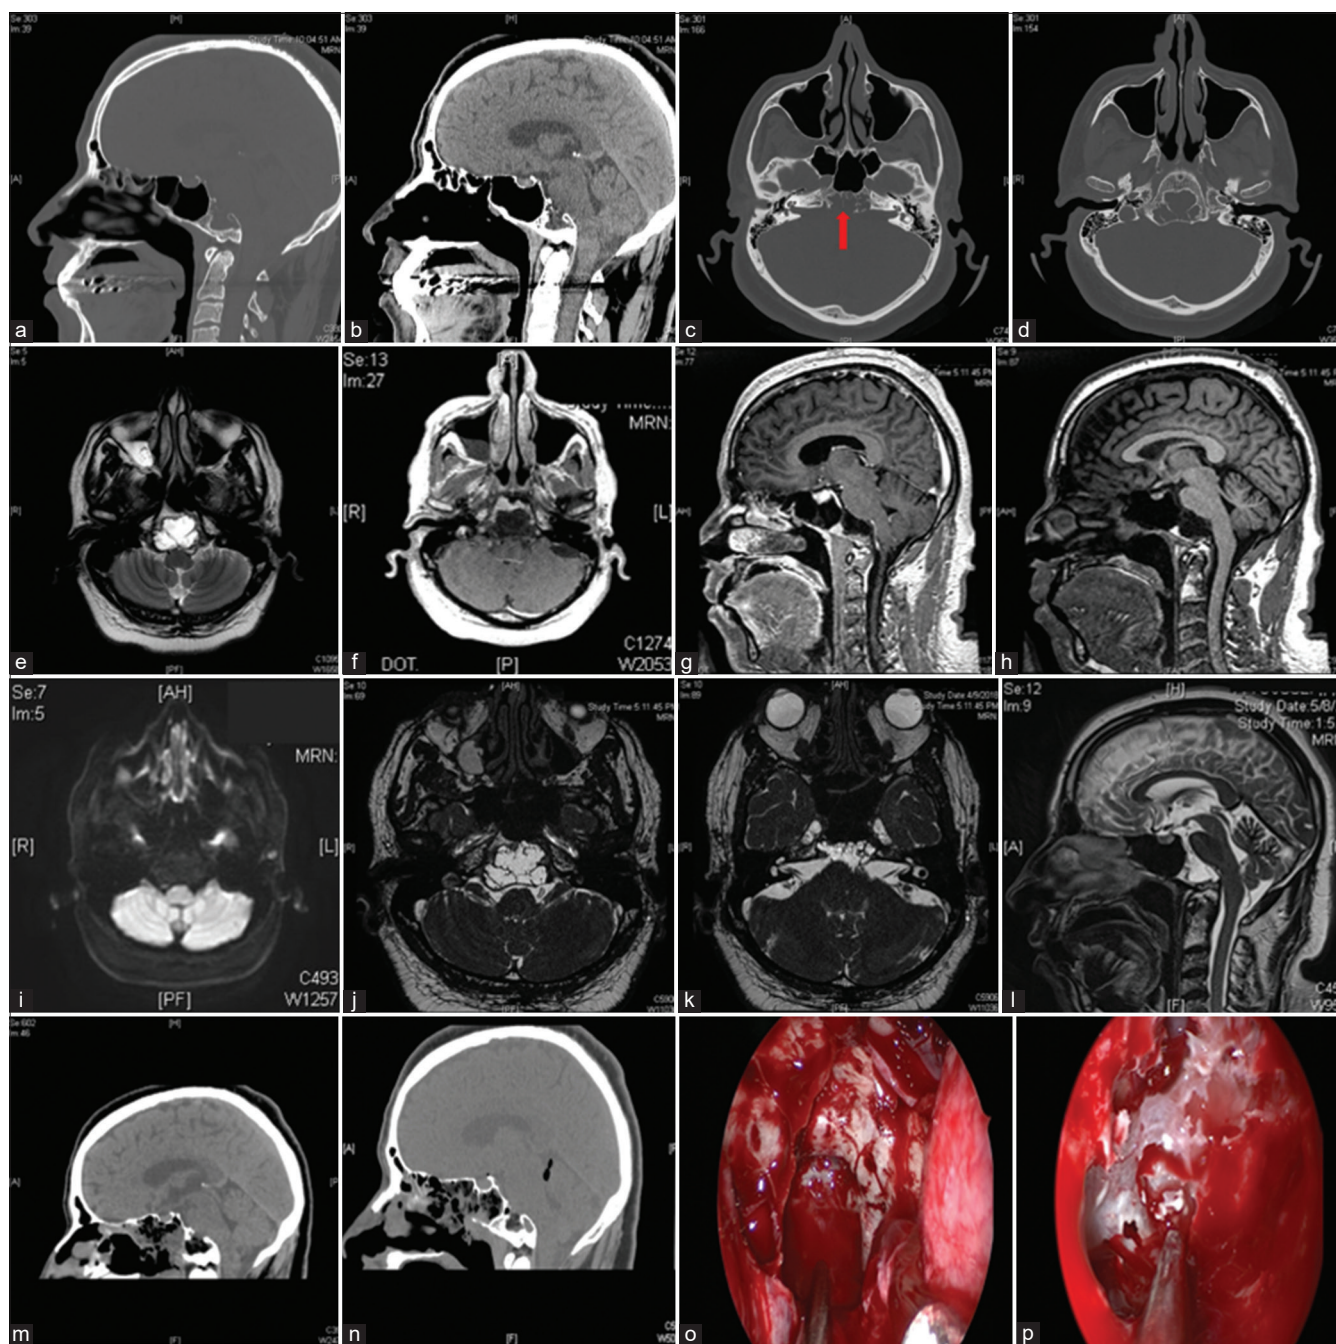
(a) Computed tomography (CT) scan, sagittal view, bone window showing the clival cyst (b) CT scan, sagittal view showing the clival cyst communicating with subarachnoid space (c) CT scan, bone window showing the clival cyst (arrow) (d) CT scan, bone window showing the clival cyst communicating with arachnoid space (e) magnetic resonance imaging (MRI), T2 sequence, axial cut (f) MRI, T1 sequence, axial view with contrast. (G) MRI, T1 sequence, sagittal view with contrast (h) MRI, T1 sequence, sagittal view (i) MRI, diffusion-weighted imaging sequence, axial view showing no restriction (j) MRI, T2 sequence, axial cut showing the clival cyst (k) MRI, T2 sequence, axial cut showing the cyst communicating with subarachnoid space (l) MRI, T2 sequence, sagittal cut showing the clival cyst communicating with subarachnoid space (m and n) Postoperative imaging post cyst drainage and cystic wall resection, the cystic cavity filled with fat graft (o) Intraoperative view of the endoscopic transnasal approach showing the cystic cavity in the clival cyst after anterior wall opening (p) Intraoperative view showing the cystic wall.
